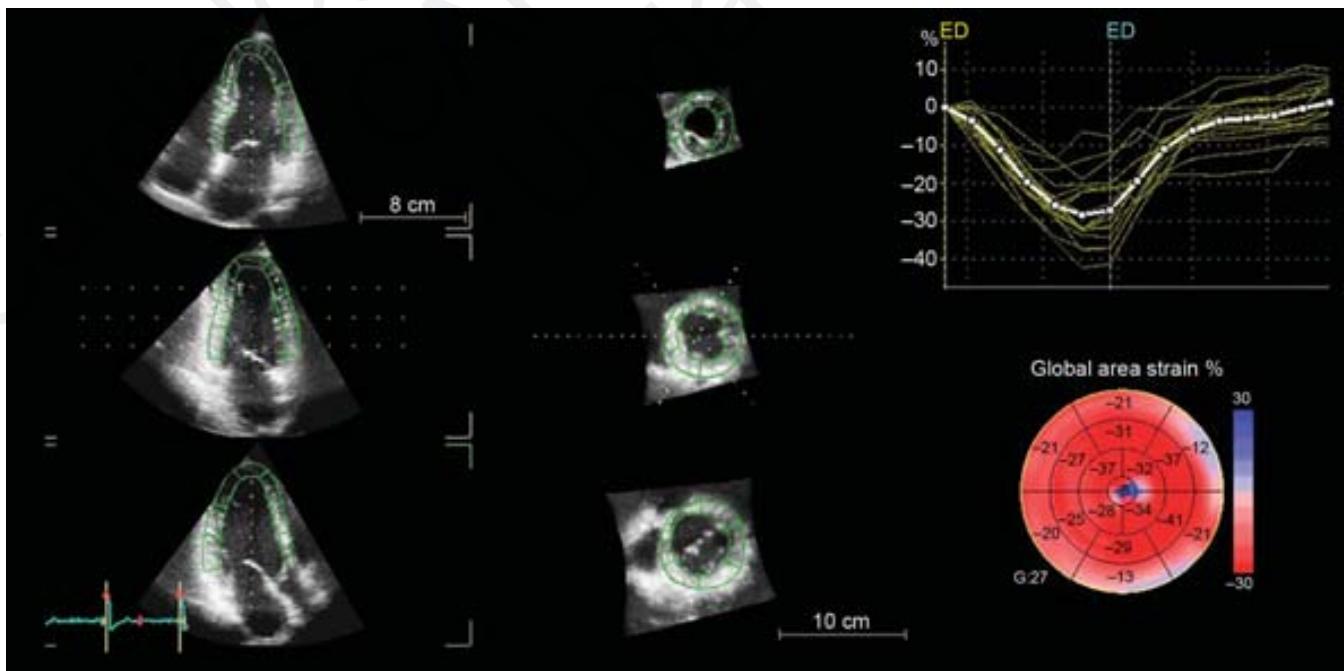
Three-dimensional speckle-tracking echocardiography. From a single volume dataset, all different components of left ventricular (LV) regional and global strain are derived. Shown in this example is LV global and segmental area strain.
